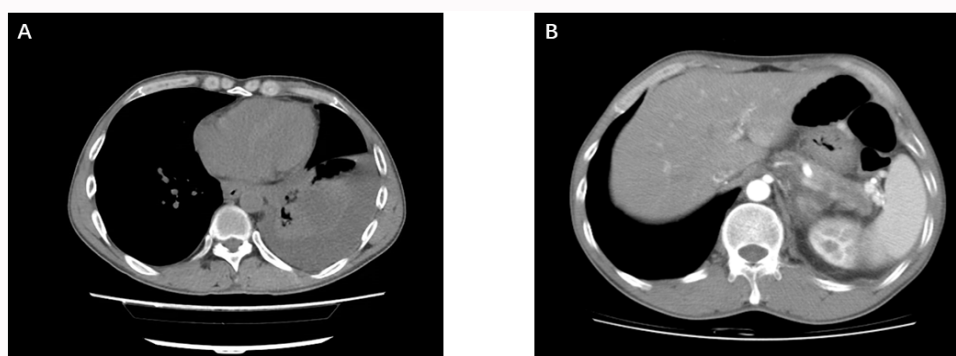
A. Chest CT showed left pleural effusion. B. Abnormal CT showed a flaky low density around Pancreatic tail.
